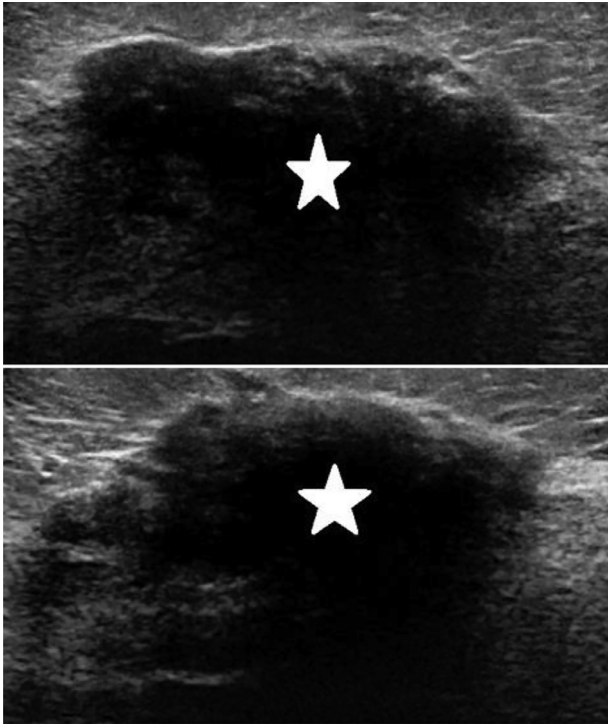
A-B: Radial and antiradial ultrasound images in August 2020 demonstrate an irregular, shadowing mass (star) with angular and subtle, spiculated margins at 1:00 4 cm from the nipple measuring 3.1 × 1.1 × 3.3 cm. This correlated with the mammographic finding, was given a BI-RADS 5 assessment, and ultimately underwent ultrasound-guided core biopsy.
